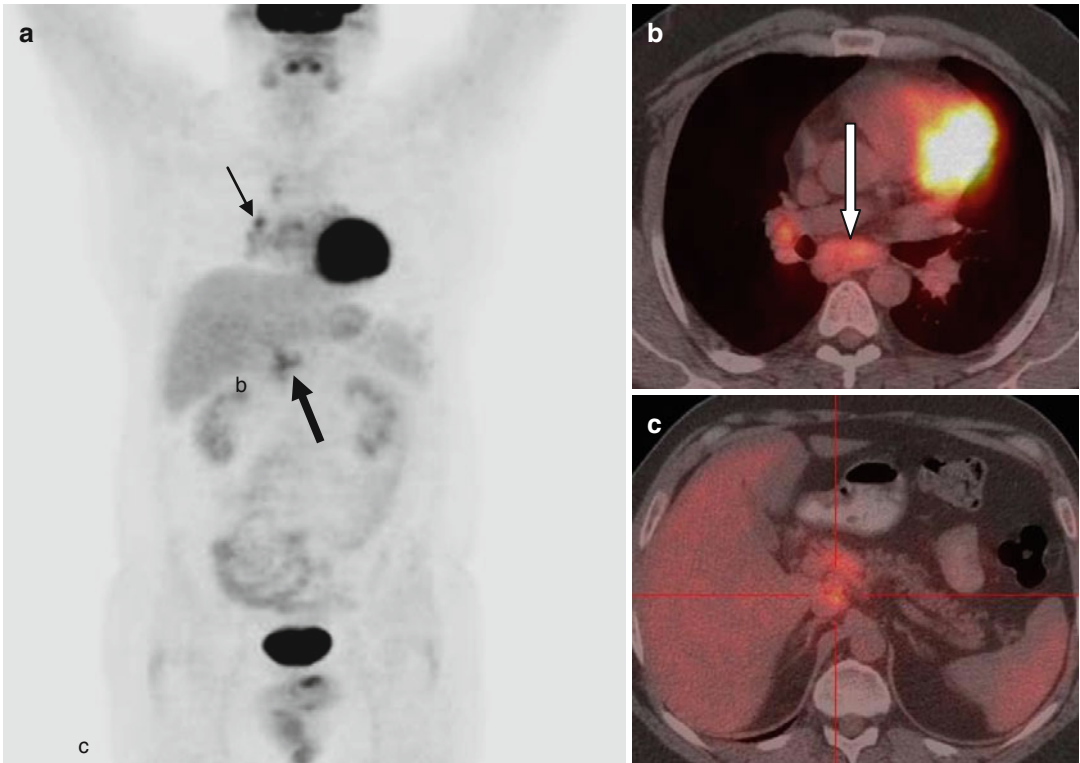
(a–c) A new PET/CT, performed 3 months after ASCT. Increased abnormal 18-FDG uptake (SUVmax 6) in multiple mediastinal lymph nodes (a, thin
